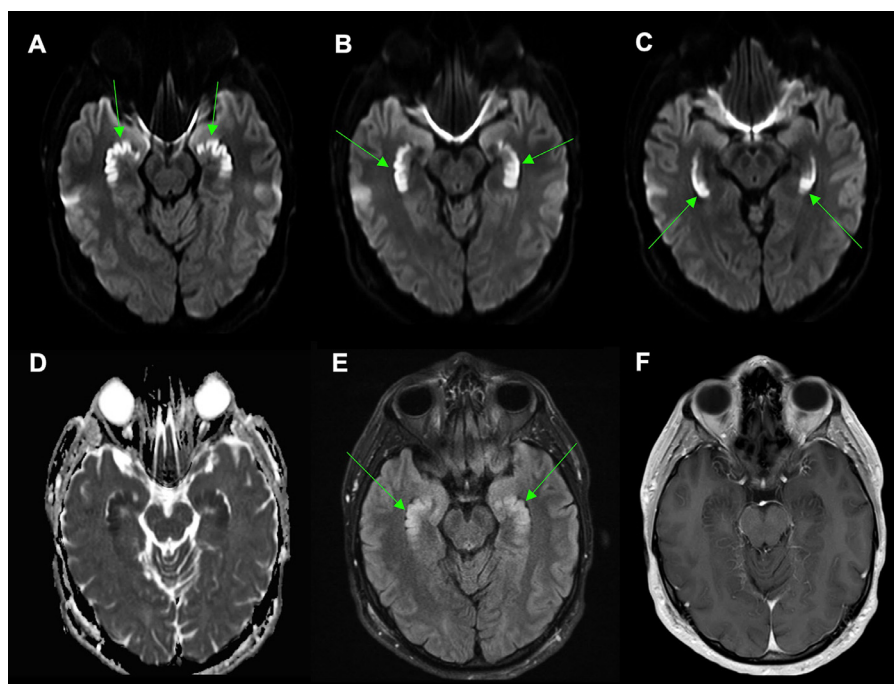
MRI of the brain without gadolinium. Diffusion-weighted imaging demonstrates bilateral, symmetric hyperintensity in the (A) heads, (B) bodies, and (C) tails of the hippocampus. (D) The apparent diffusion coefficient correlate map shows a corresponding low signal consistent with diffusion restriction. (E) Abnormal T2 fluid-attenuated inversion recovery hyperintensity is present in the Hippocampi. (F) Axial T1-weighted imaging shows no abnormal contrast enhancement.
